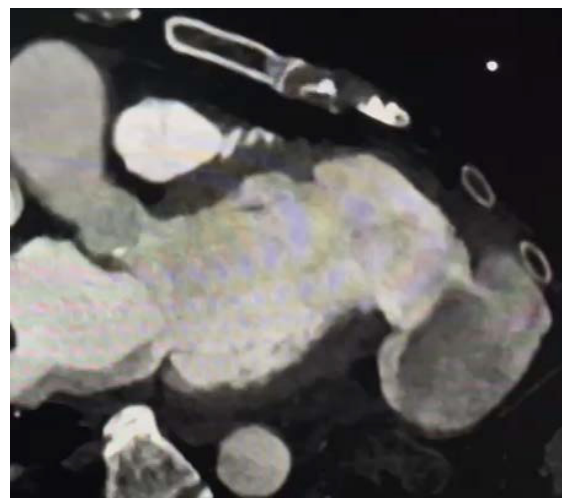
Left ventricle CT with ventricular aneurysm, pseudoaneurysm and active flow jets [2].
